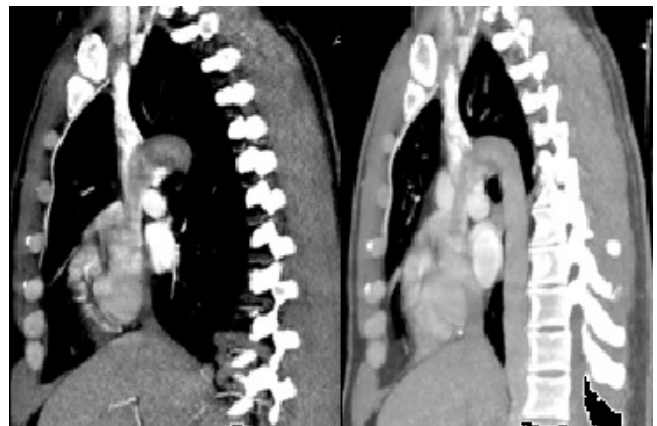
The sagittal enhanced CT view shows, enlarged azygos vein, descending on the right side of the aorta and drain into the vena cava superior. The hepatic segment is not detected and hepatic veins directly drain into the right atrium.
